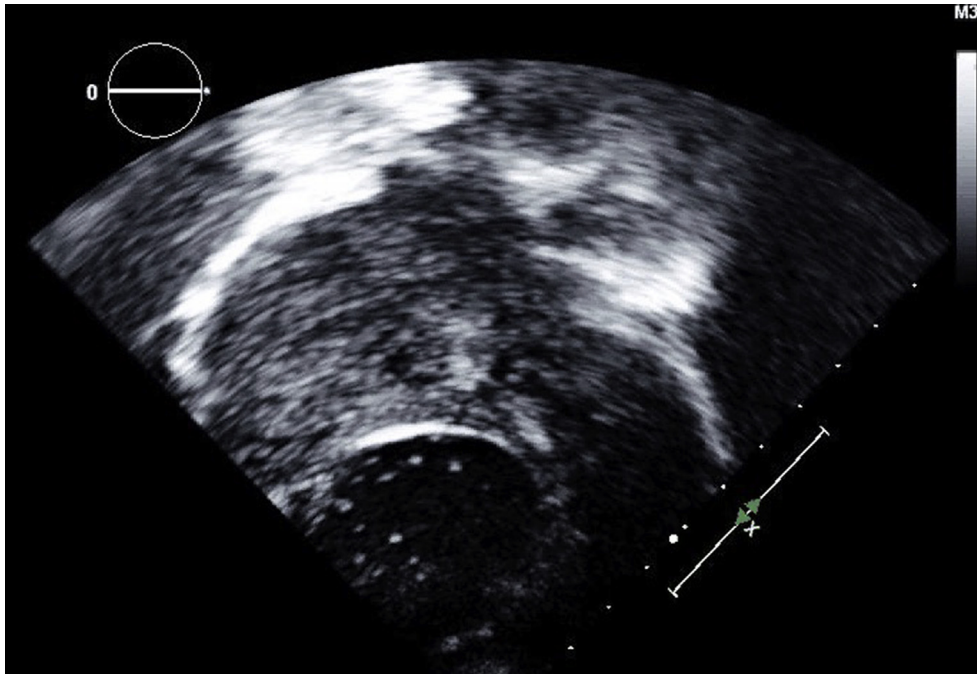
Transthoracic echocardiogram: apical four-chamber view with agitated saline contrast showing contrast entering the fluid-filled space enclosed within the dissection flap indicating direct communication with the cardiac cavity.
